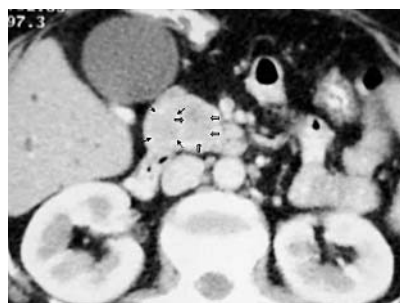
Computed tomography (CT) showed a solid mass, located inferiorly to the pancreatic head and uncinate process. The mass enhanced similarly with pancreatic parenchyma at the early arterial phase. Preoperatively, the mass was interpreted as being located in the pancreatic head. CT images were evaluated retrospectively with the findings at surgery and two different lesions were differentiated (arrows).
